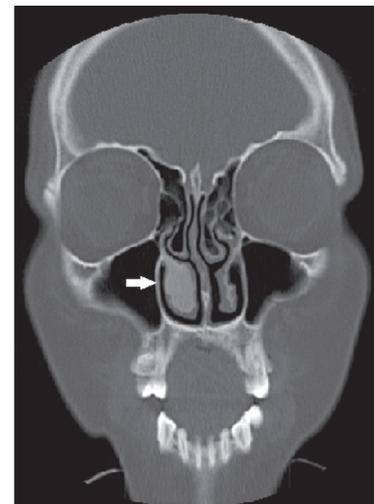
CT of the paranasal sinus showing a ground-glass opacity causing expansion of the right inferior turbinate (arrow).
